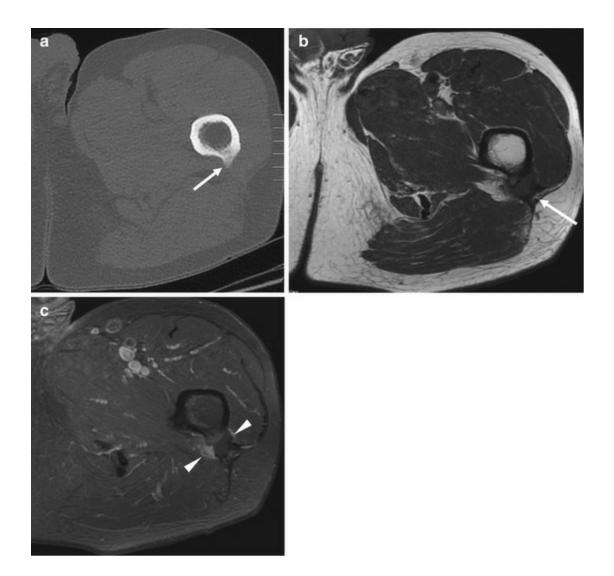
A 70-year-old man with a painful cortical irregularity of the posterior femur. (a) Axial CT image shows a discrete rarefaction of the posterior femoral cortex, associated with a enthesophyte formation (*arrow*). (b) Axial T1-weighted MRI shows marked thickening of the deep insertion of the gluteus maximus tendon at the femur (*arrow*). (c) Axial fat-suppressed contras-enhanced T1-weighted MRI shows the enhancement adjacent to the enthesophyte (*arrowheads*). These findings are evocative of an inflammatory gluteal tendinopathy
